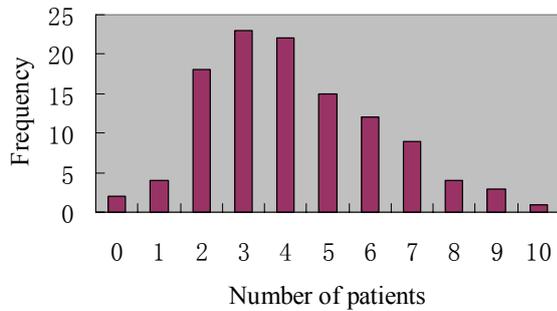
Frequency histogram of B-ultrasound arrival time
